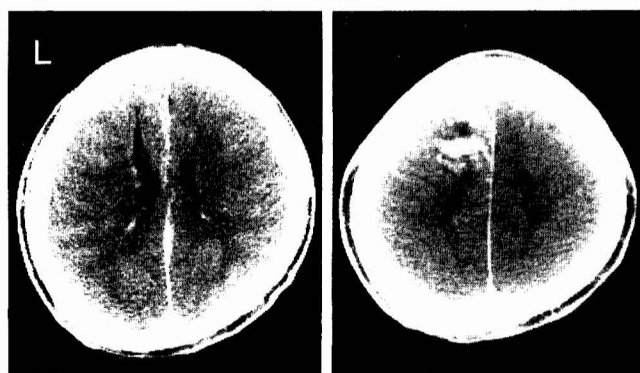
CT on the second admission reveals a ringed high density area with marked enhancement and a linear low density area in the left posterior frontal lobe.
